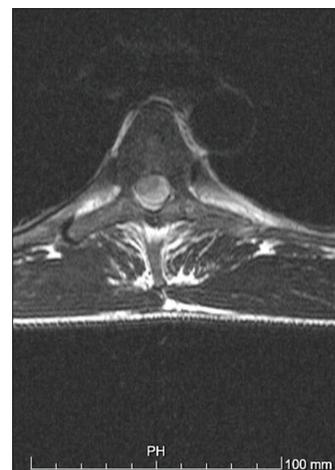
T2-weighted axial thoracic spine MRI.
